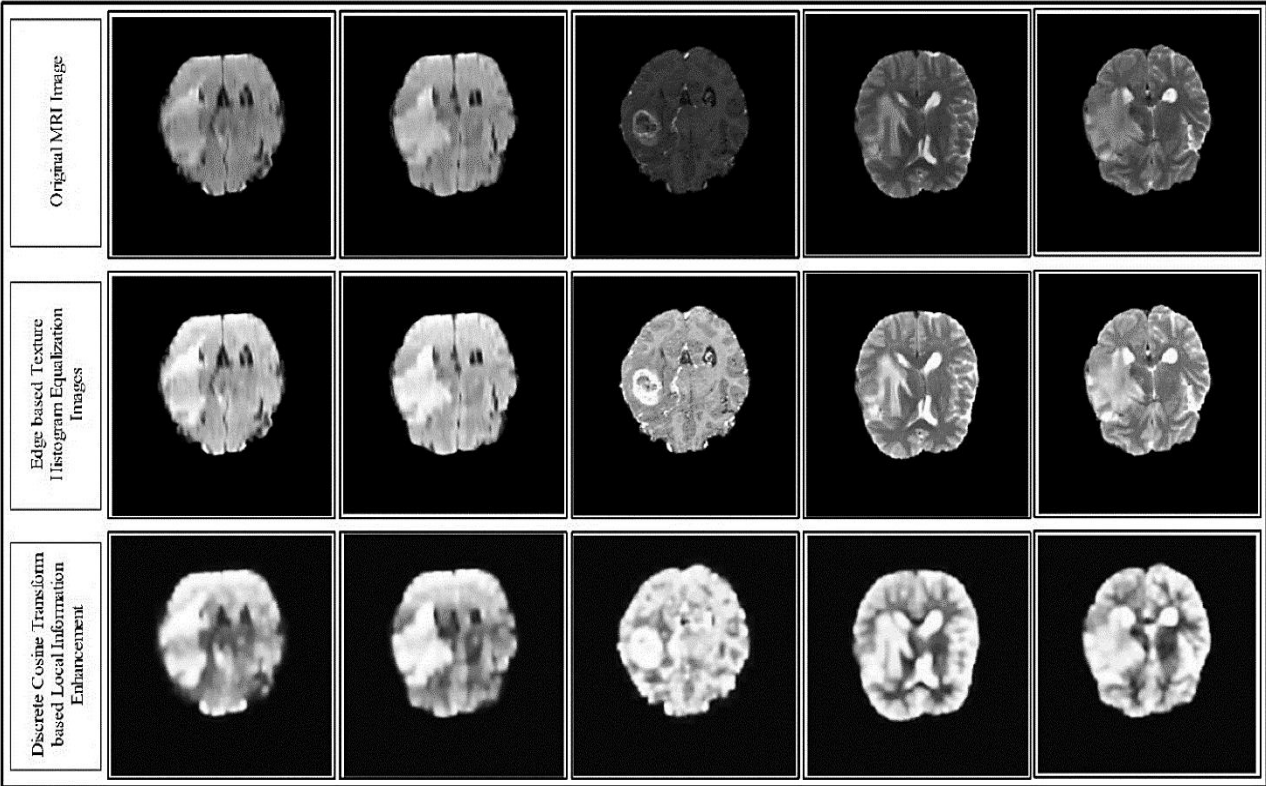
Enhanced MRI scans demonstrating the impact of hybrid local contrast techniques on tumor visibility for subtype classification in BRATS dataset.
